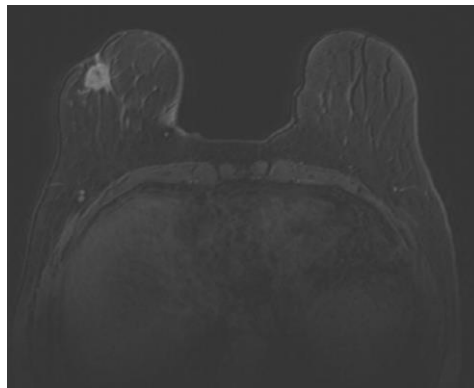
Example of an axial plane MRI image using the *THRIVE 7 din SENSE* protocol from the repository provided by IPO.
